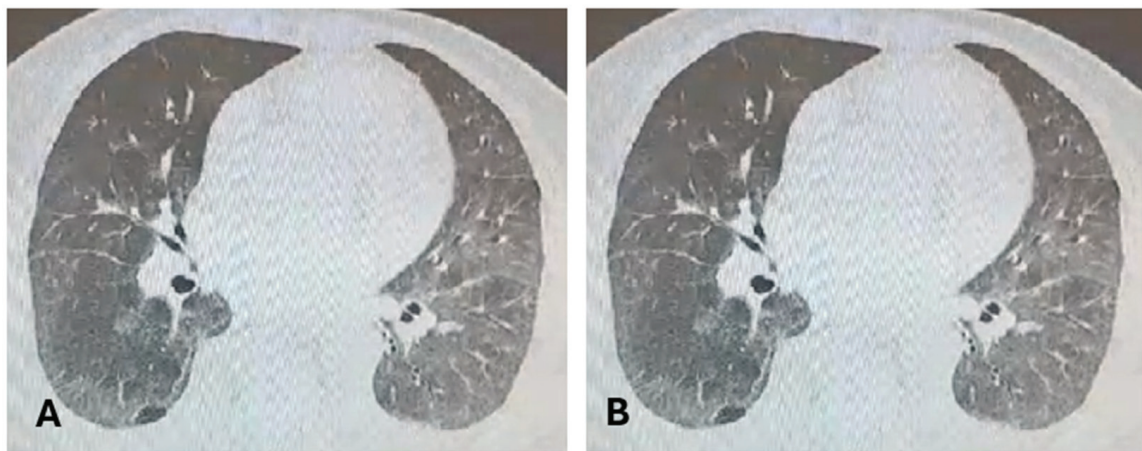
Chest CT September 2022. (A) NSIP-like appearance; (B) basal aspect of NSIP-like bilateral infiltrates.
